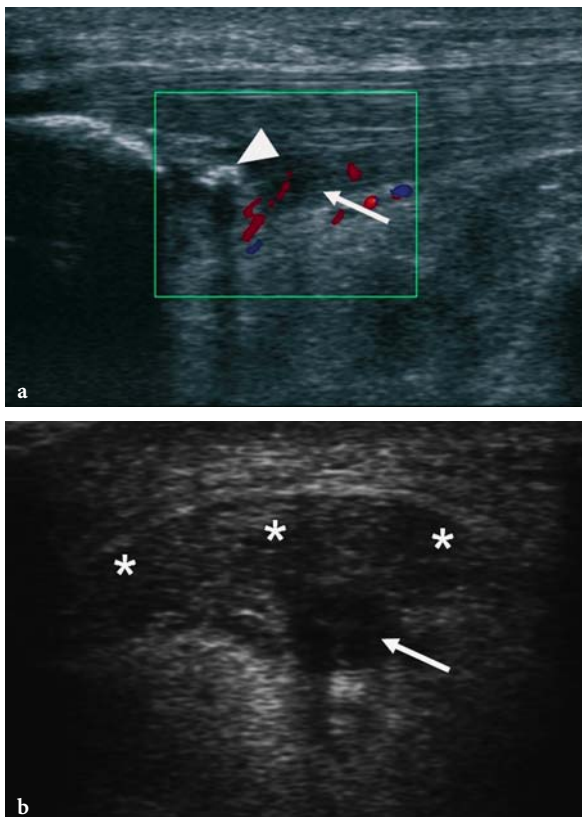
Patellar tendinosis: a sagittal; b axial ultrasound showing a focal hypervascular mass in the deep portion of the proximal end of the patellar tendon (arrows). There is some calcification (arrowhead). Asterisk mark the tendon; c sagittal proton density fat suppressed MR image in a different case showing typical focal high signal deep to the tendon near its origin (open arrow)
